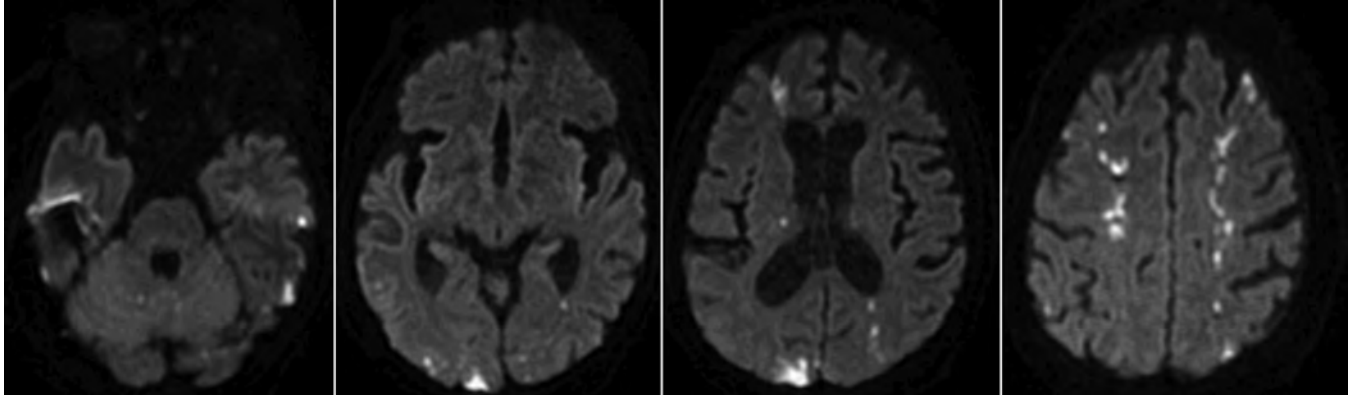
Diffusion-weighted magnetic resonance imaging in a 64-year-old woman with altered level of consciousness showing multiple foci of restricted diffusion in the cerebral hemispheres (frontal, parietal, occipital and temporal), basal ganglia and posterior fossa, suggestive of a multiterritorial stroke.
